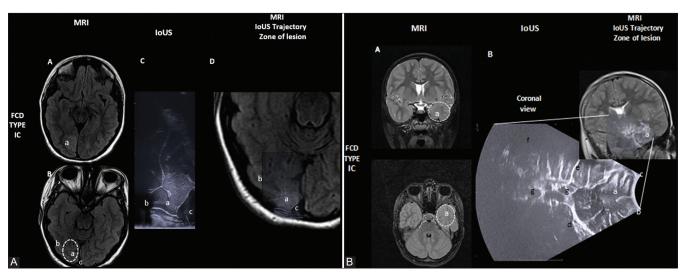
A. FCD TYPE Ic A, B. MRI Flair in Axial view highlighting Rt Occipital FCD Type Ic (dashed lines). C, D; - depicting combined MRI and IoUS trajectory to the zone of FCD lesion with clearly visualized adjacent anatomical structures. a- FCD Type Ic; b - Rt Occipital lobe; c - Superior Sagittal Sinus. B. FCD TYPE Ic A;- MRI T2WI Coronal and MRI Flair Axial images depicting localization of Left temporal FCD Type Ic (dashed lines). B - highlighting coronal IoUS with combined coronal Mri and IoUS trajectory to the zone of FCD lesion clearly depicting adjacent anatomical structures; a - FCD Type Ic, b - left inferior temporal gyrus, c- middle temporal gyrus, d -cavernous sinus. ginternal carotid artery, e-internal capsule, f- third ventricle.
